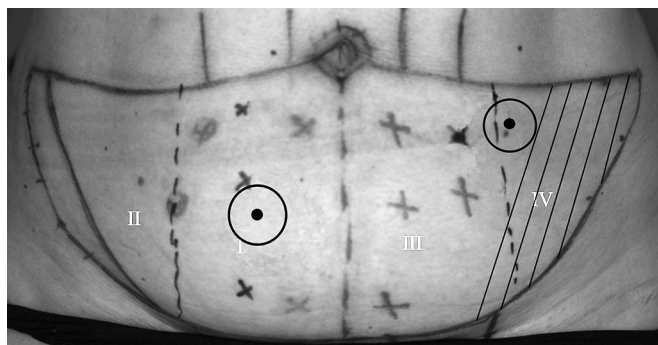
Zone classification and LDF measurement sites. I–IV, Blood flow zones. The black point within the circle represents the laser Doppler flowmetry sites. Ipsilateral to the vascular pedicle, the LDF probe holder in zone I is sutured between the medial and lateral row of the perforators, whereas the second holder is sutured at the medial border in zone IV. The shaded area represents the part of the flap (zones III and IV), which was discarded to a variable degree, depending on the volume needed for reconstruction.
